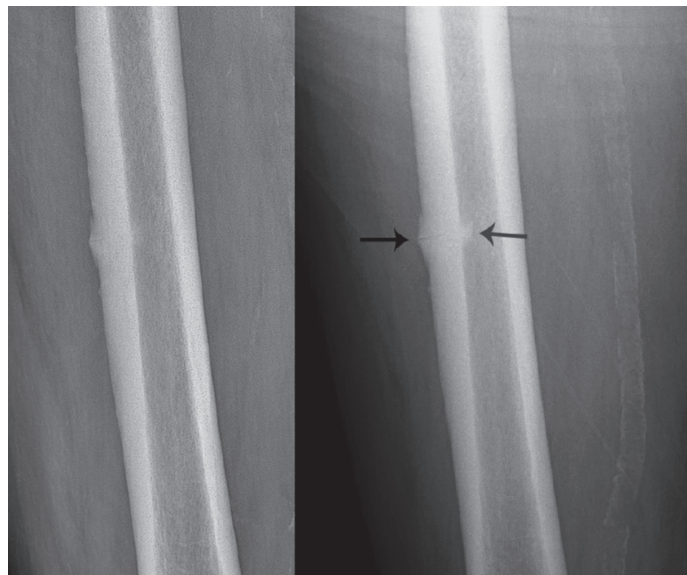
Initial radiography (left) and follow-up radiography (right) of the right femur after 2 months. Marked periosteal (black arrow) and endosteal (grey arrow) reaction around a fine transversal cortical translucency originating from a thickened lateral cortex. Severe calcification of the femoral artery.
